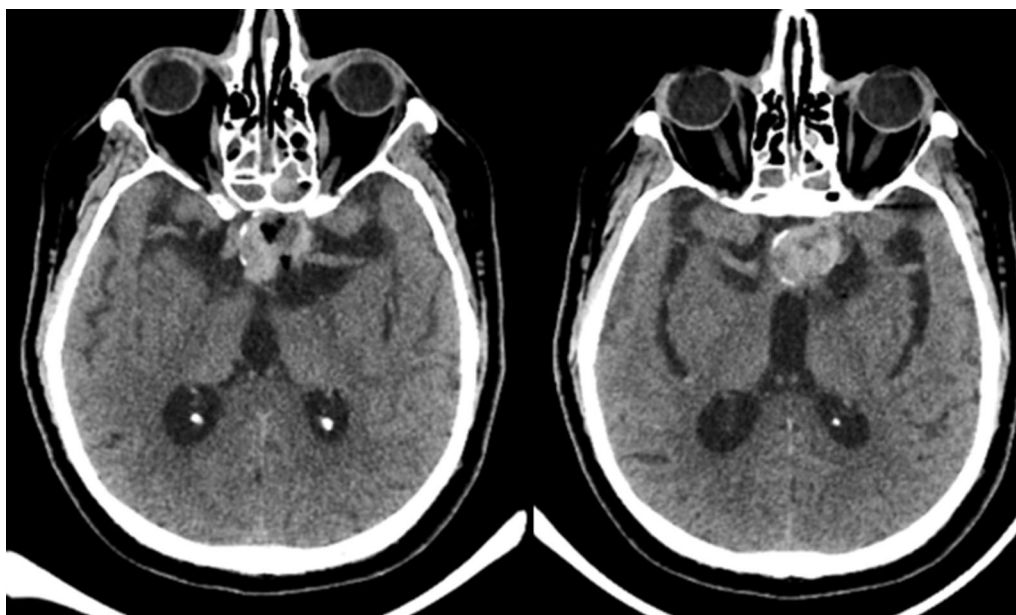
Computed tomography of the brain in the axial plane showing a hyperdense lesion in the suprasellar region compatible with intrasellar hemorrhage
